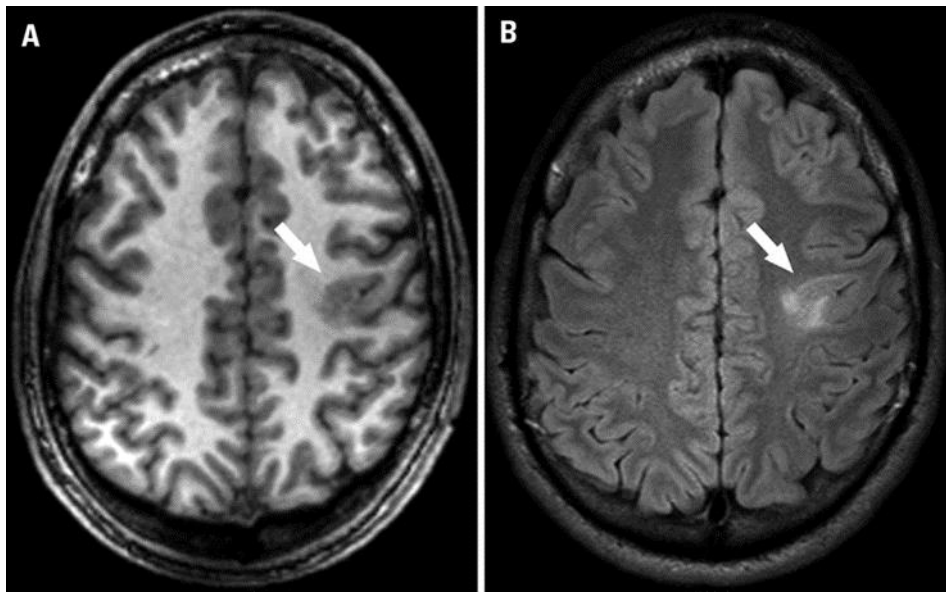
Showing FCD, an area of mild cortical thickening, with blurring of the white-gray matter interface in the left frontal lobe in the T1 FFE (fast field echo) axial image (arrow in A), that is also visualized in the FLAIR axial image, along with hyperintense signal in the underlying white matter (arrow in B).
